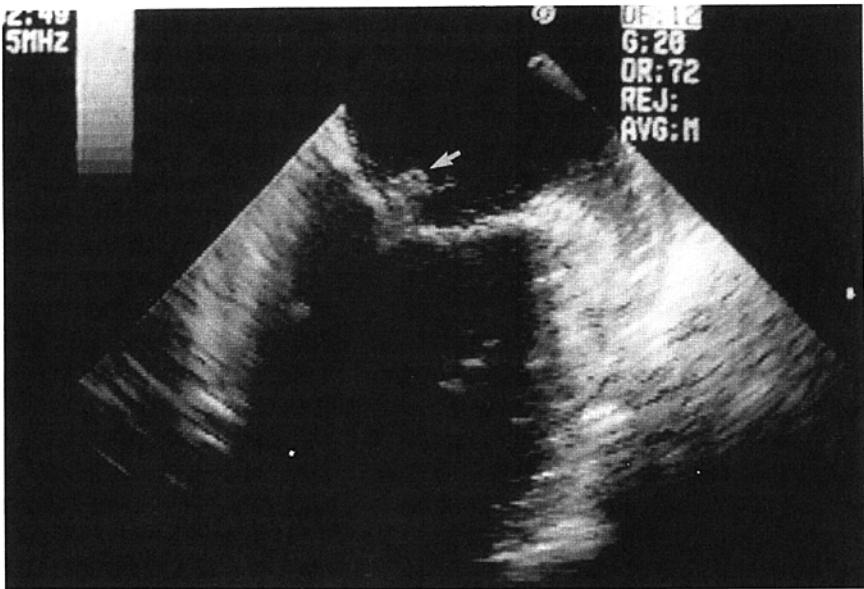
Vegetation on a mitral valve. Transesophageal sonogram through the mitral valve shows a vegetation (arrow) in a patient with endocarditis. Note visualization of the left atrial appendage, normally not seen with transthoracic echocardiography. (Courtesy of Dr. Greg Schwartz, Veterans Administration Medical Center, San Francisco, California.)
